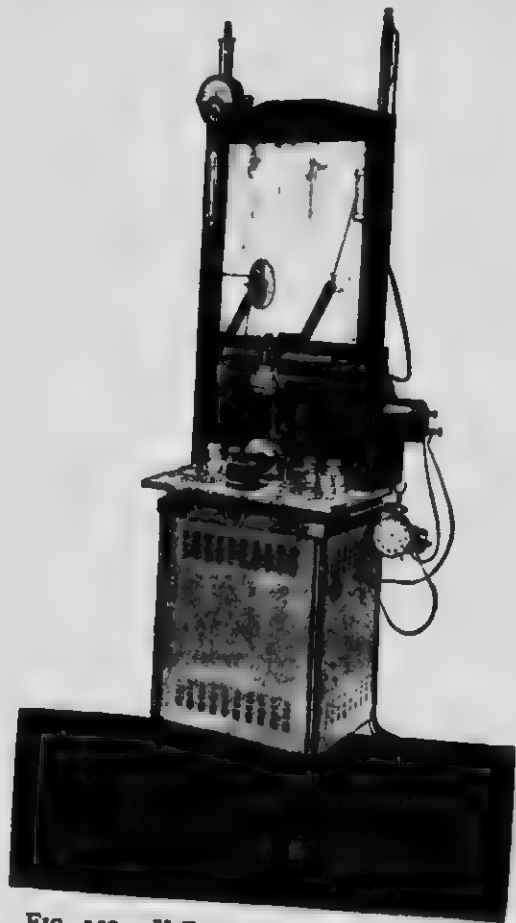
X-RAY OUTFIT ON TROLLEY.
